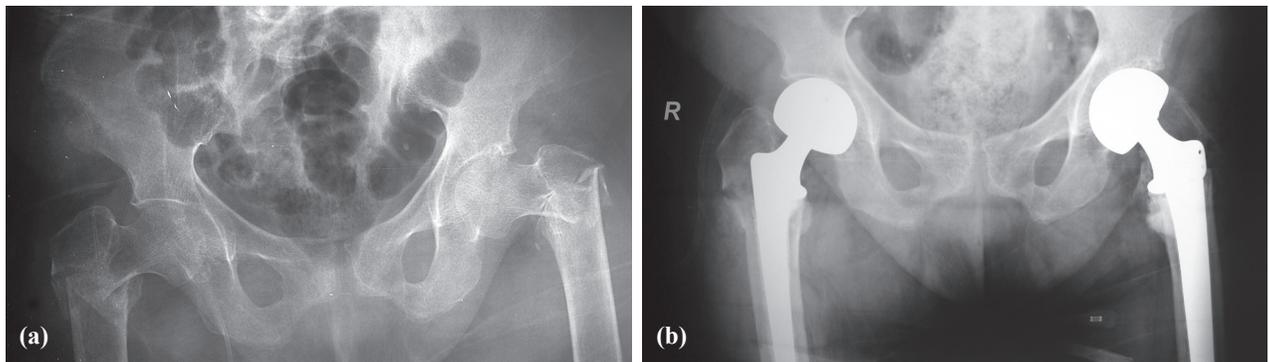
(a) Preoperative roentgenogram. (b) Postoperative roentgenogram.
